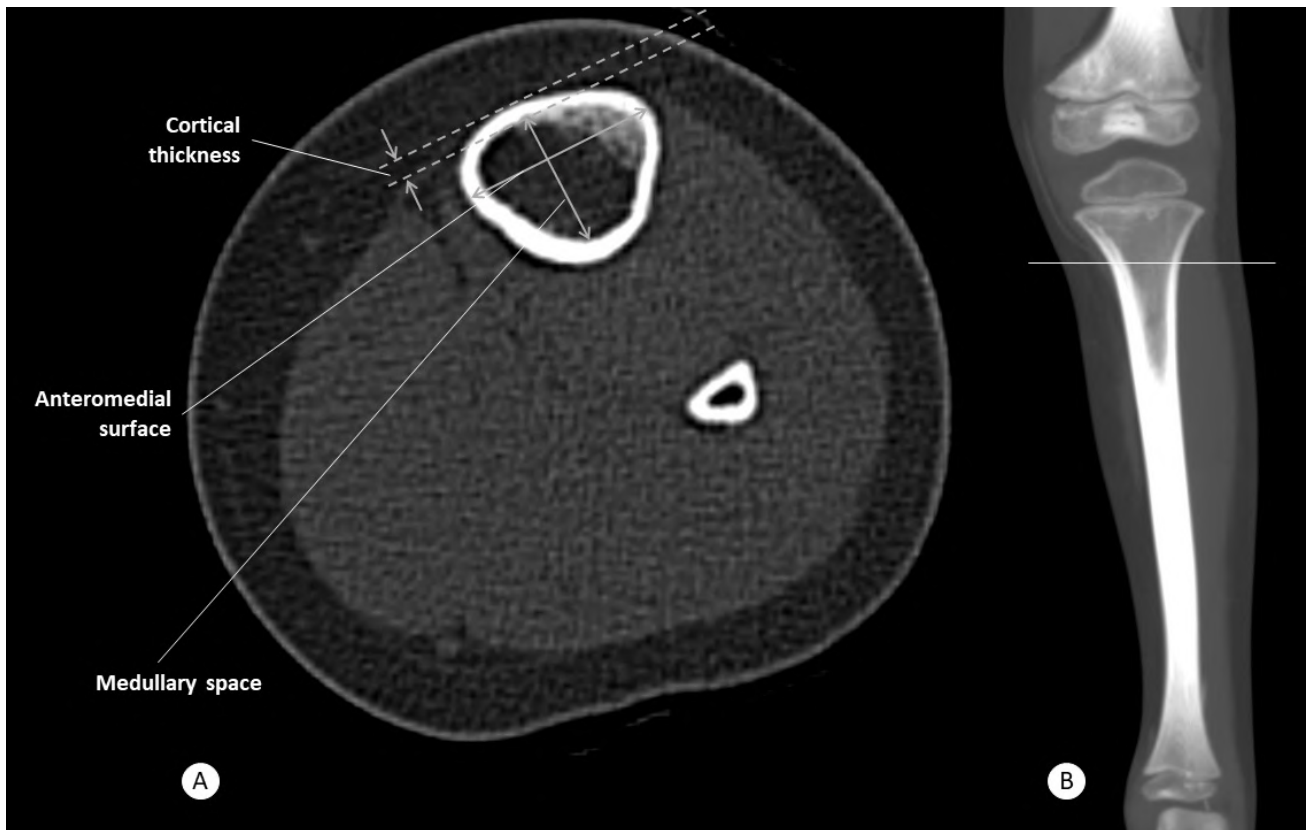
A. Transverse CT scan distal to the tibial tuberosity in a 3-year-old child. The measurements show the anteromedial surface, cortical thickness, and medullary space. B. Indicate line at which horizontal section was determined.
